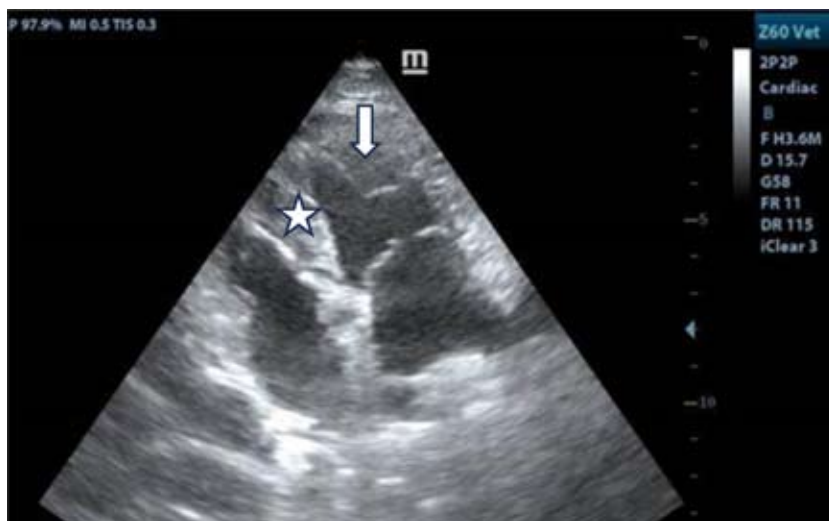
Echocardiography – Left apical view showing thickening of inter-ventricular septum(star) and the free wall of the left ventricle (arrow)
